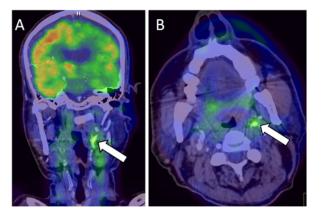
18F-FDG PET-CT imaging shows increased uptake of 18F-FDG in left ICA plaque on coronal (A) and axial plane (B), suggestive of acute inflammation.
